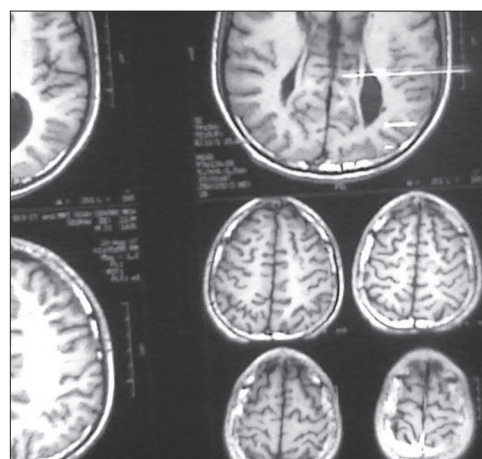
Axial T1 MRI showing prominent interdigitations of gyri
